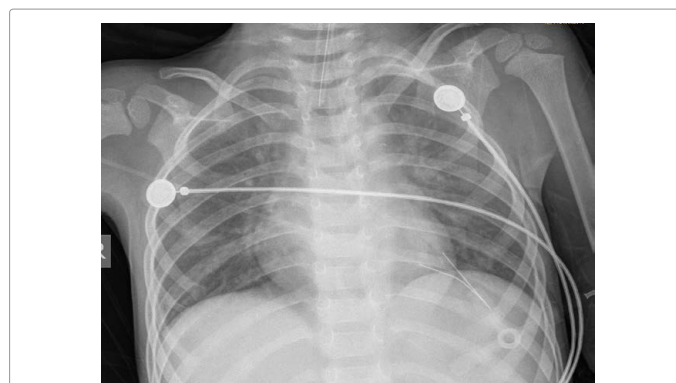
Chest X-ray in AP position: Increased and obscure texture of bilateral lungs.
